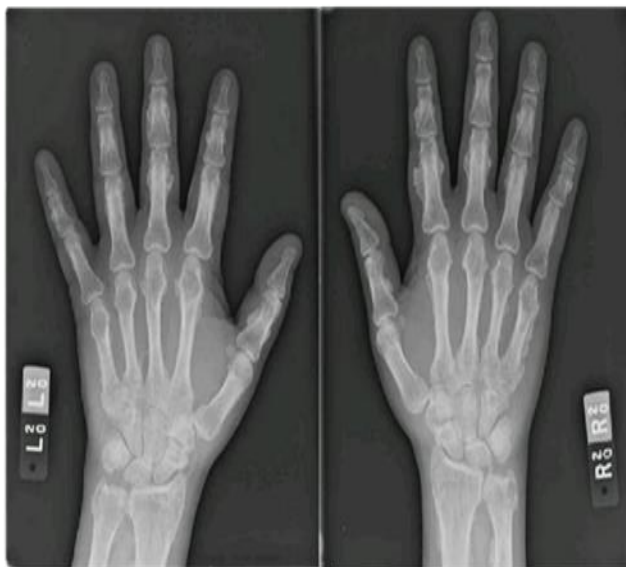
X-ray bilateral hand PA view
